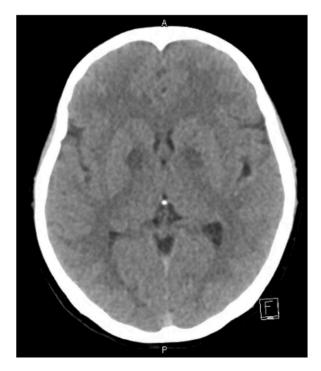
Computerized tomography (CT) scan of the head showing hypodensities within the globus pallidus of both lentiform nucleus.
